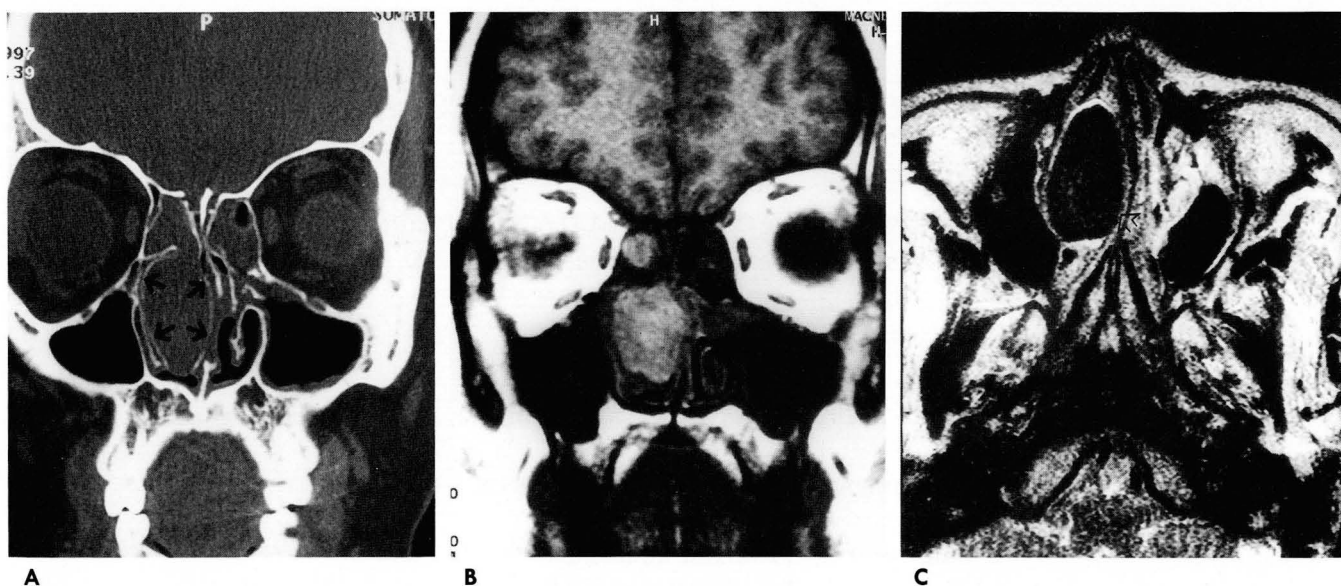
A. Coronal CT scan of the nasal cavity reveals an oval soft tissue mass with calcific rim (arrows). The nasal septum is displaced to the left side.
